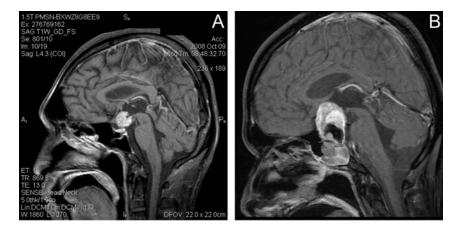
MRI T1W galdolinium enhancement showed (A) galdolinium enhancing craniopharygioma extended to anterior part of the third ventricle. (B) galdolinium enhancing gonadotroph pituitary adenoma extended to suprasellar region
